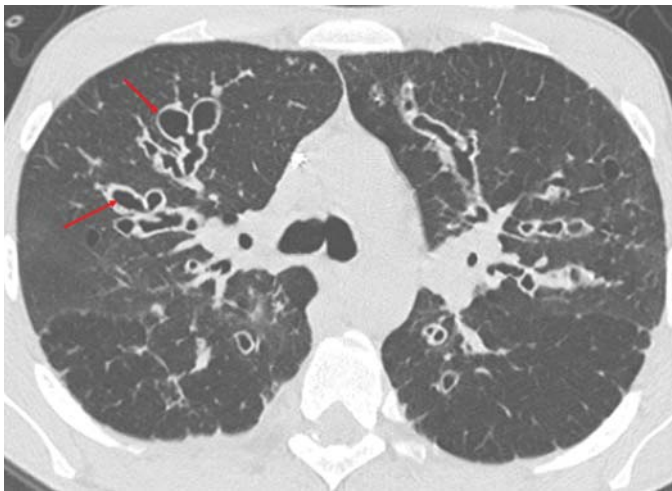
FIGURE e24-32 CT scan of diffuse, cystic bronchiectasis (red arrows) in a patient with cystic fibrosis.
